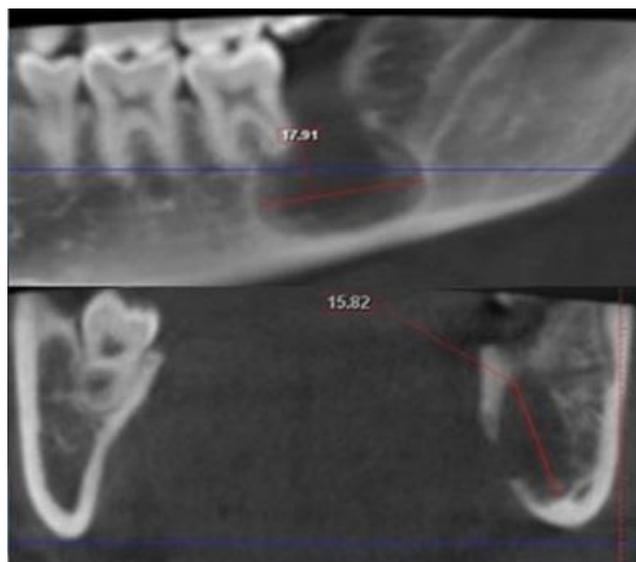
A) OPG revealing the presence of a horizontally impacted tooth and a well-defined unilocular radiolucent lesion with a sclerotic margin and which is association with the lateral aspect of the impacted tooth near the CEJ, B) Axial, sagittal and coronal slices of CT showing a unilocular hypodense lesion in relation to 38 region with erosion of the lingual cortical plate.
